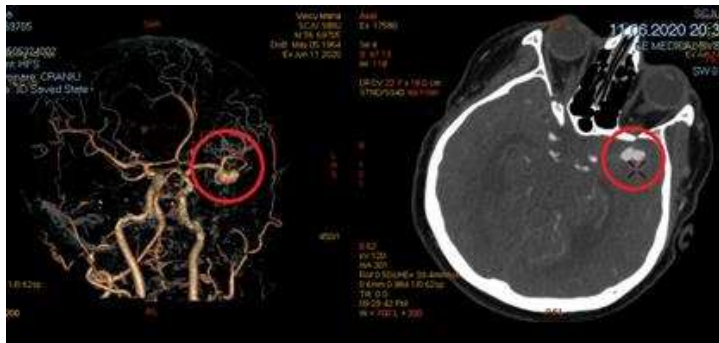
CT images of a real case of MCA aneurysm.
